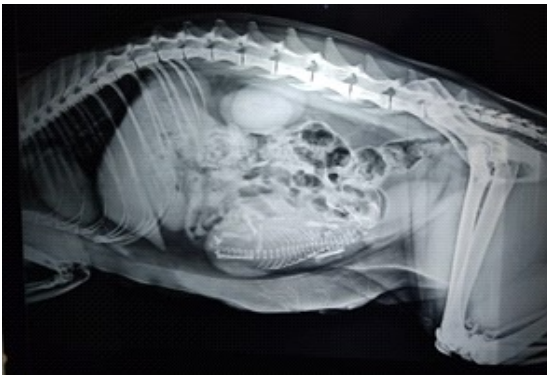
Lateral abdominal radiograph revealed single fetus inside uterus in anterior presentation
